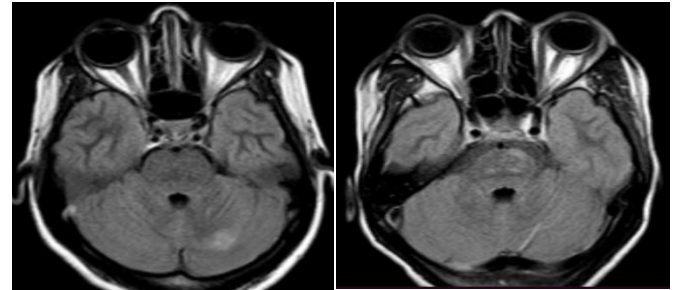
Axial FLAIR images show edema involving left cerebellum and brainstem, suggesting Atypical PRES
